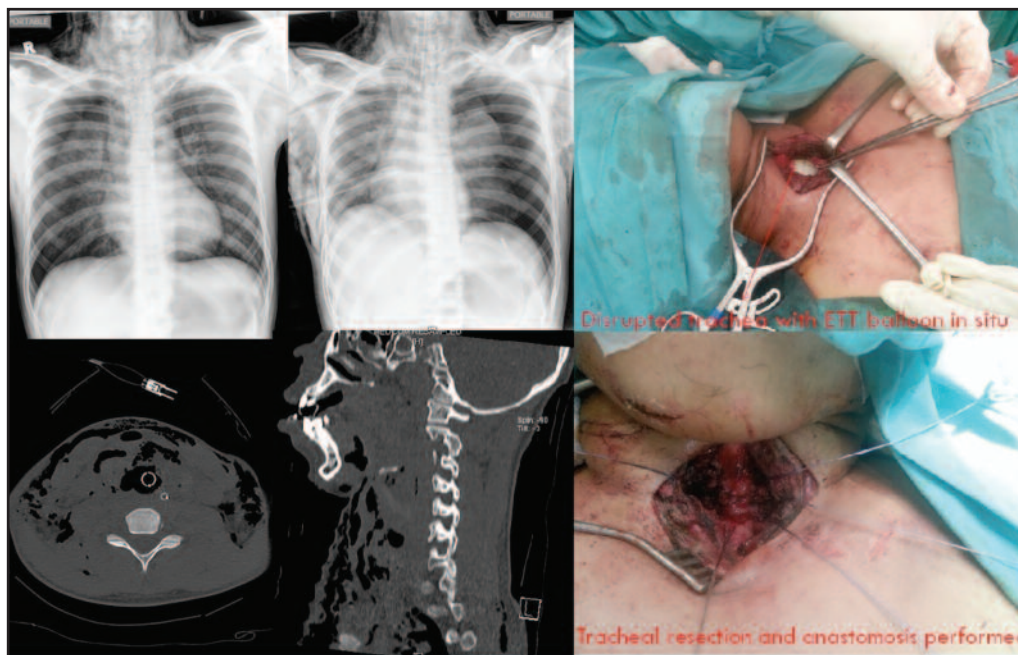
Chest radiograph^a, CT cervical^b and Operative procedure^c performed in the first case.
